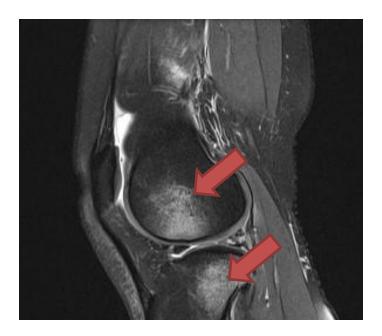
MRI of knee, SAG proton density (PD) weighted images. Bone edema on medial condyle of tibia and femur.
